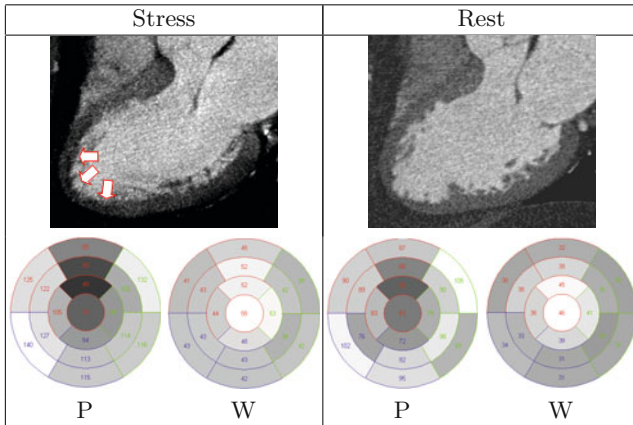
Visual and quantitative comparison of the stress and rest CT perfusion images
